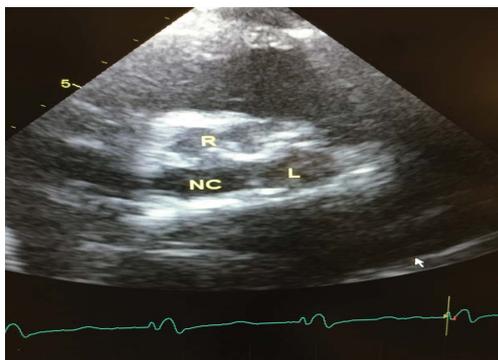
Image from transcutaneous ultrasound showing three cusps. This is reference for adjustment of the fluoroscopic equipment giving a good radiological alignment of the cusps without need for contrast.
